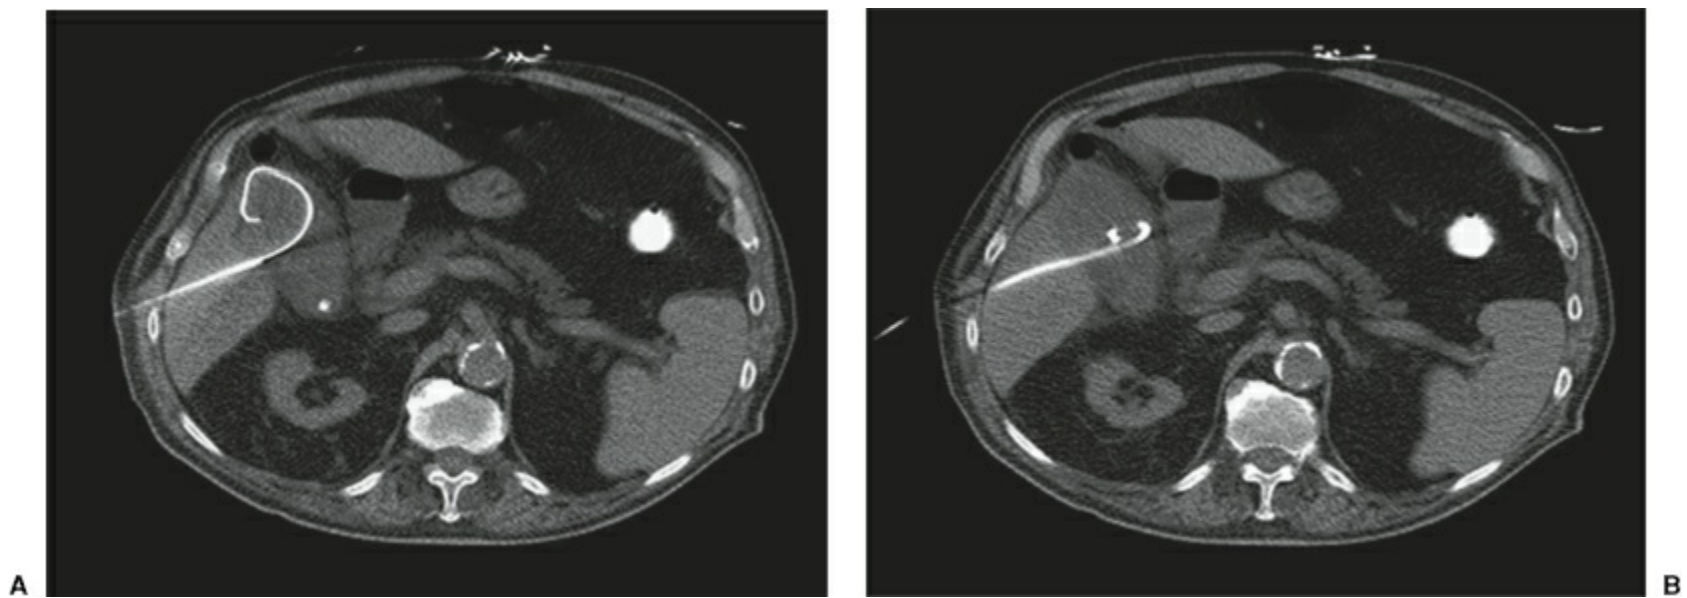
CT guided placement of a 10-French cholecystostomy tube for acute cholecystitis in a nonoperative patient. Note transhepatic (across the liver) placement. These tubes may be placed using US or CT guidance. (Image courtesy of Aarti Sekhar, MD and David Schuster, MD, Emory University Department of Radiology.)
